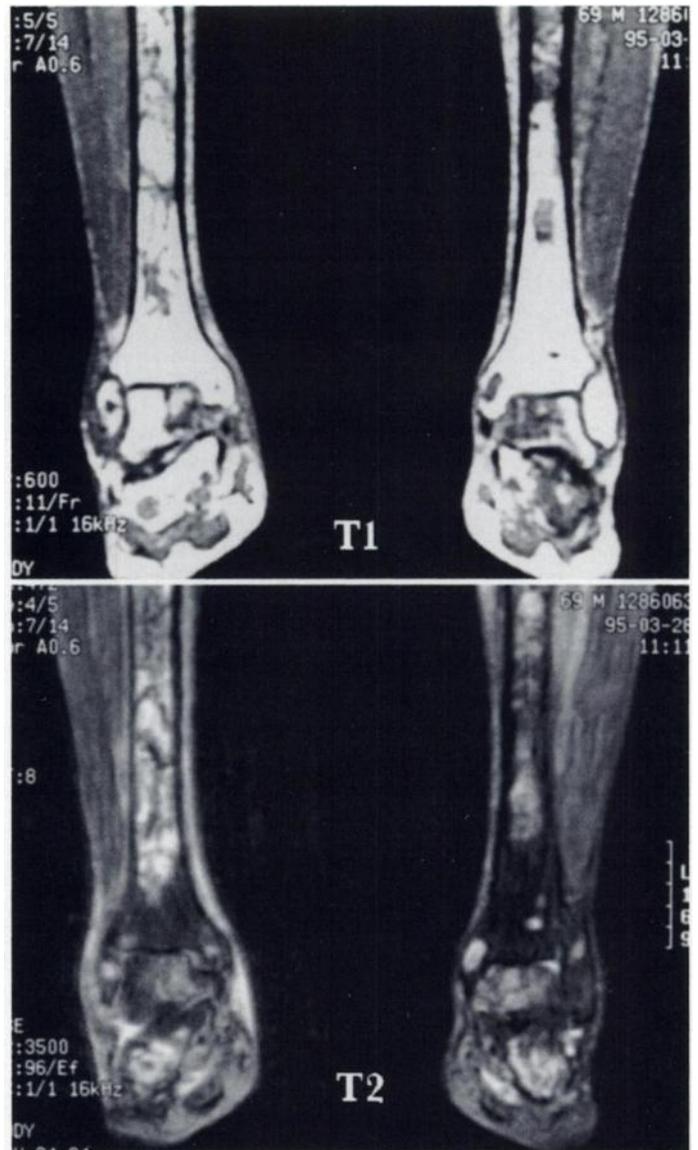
Coronal MR images. (Top) T1-weighted MR image shows diminished signal intensity. (Bottom) T2-weighted MR image shows areas of decreased signal intensity within a region of overall increased signal intensity in diaphysis and metaphysis of both tibias.
